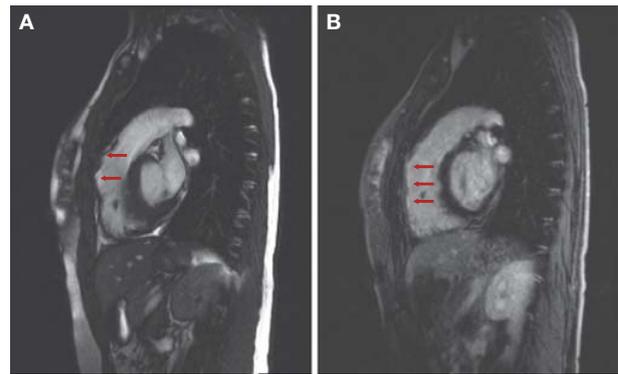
Findings of contrast-enhanced cardiac magnetic resonance (MR) A) Systolic frame of cine MR image of right ventricular (RV) outflow tract showing ventricular aneurysms of anterolateral wall (arrows). B) Post-contrast sequences showing the presence of late gadolinium enhancement (bright signal intensity) in the RV outflow tract (arrows), that is the same region of ventricular aneurysms.
